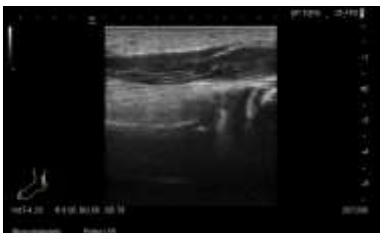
Ultrasonography revealed a diffuse interdigitating network of elongated heterogeneous tumors along the long axis of the nerve in longitudinal section, and “target sign” on transverse scan.
